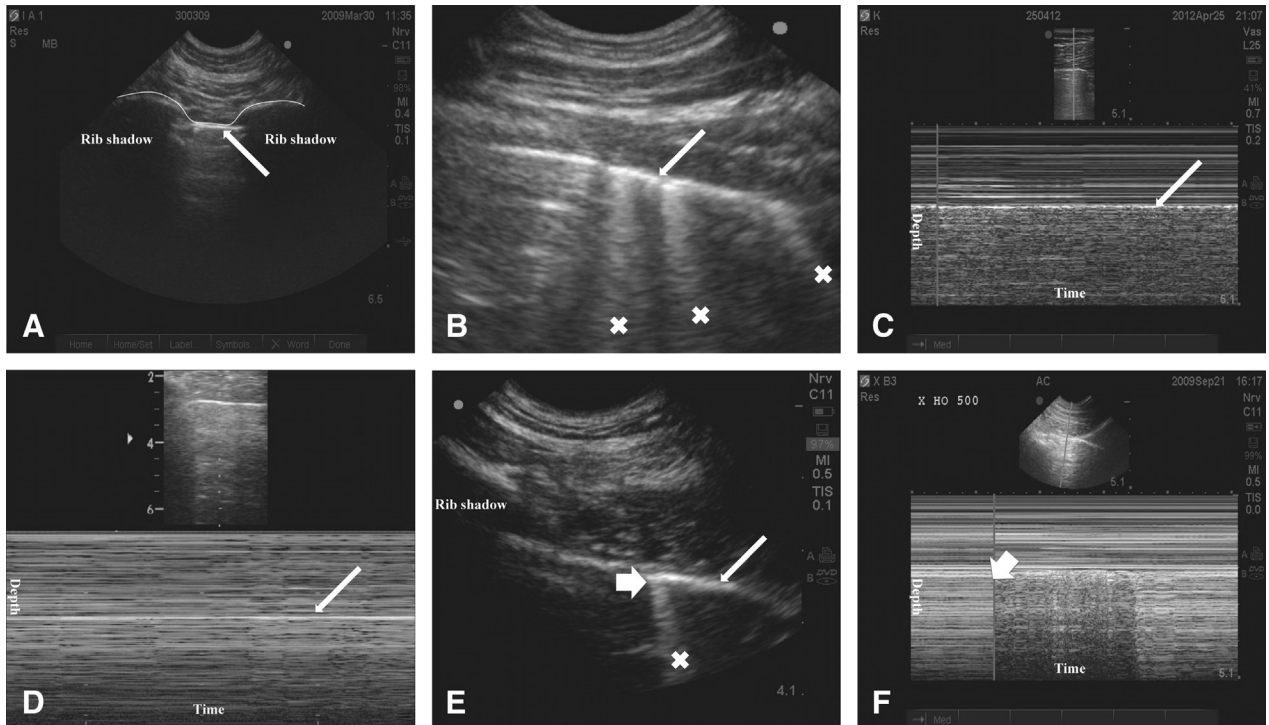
Algorithm to diagnose a pneumothorax (PTX). Throughout the figure, thin arrows point at the pleural line and X marks artifacts extending from the pleural line to the bottom of the screen, called B-lines. Thick arrows indicate the lung points. (A) The bat sign: On a longitudinal scan at the anterior chest, two ribs with the pleural line in-between are identified (this image resembles a bat, as shown by the thin white line). (B) Detection of lung sliding or B-lines: This image is obtained by rotating the probe approximately 90 degrees to align in the intercostal space and then gradually moved toward the lateral-posterior parts of the chest. The aim is to detect the presence or absence of horizontal movements of the pleural layers, called lung sliding (visible only on video clips) or B-lines. Lung sliding or B-lines rule out PTX, and both signs are absent if the pleural layers are separated by air. (C) Seashore sign: Time motion-mode from image B. When lung sliding is present, the image has a granular appearance under the pleural line (resembling sand) and horizontal lines above the pleural line (resembling the horizon). (D) Stratosphere sign: Abolished lung sliding can also be visualized in time motion-mode. Notice here the straight horizontal lines throughout the image in contrast to image (C). (E) Lung point: The boarder between the intrapleural air and the part of the lung still in contact with the interior chest wall is called the lung point (thick arrow). It appears on the screen as two distinct sonographic patterns that interchange synchronous with respiration (visible only on video clips). Identification of the lung point is 100% specific for PTX. (F) Lung point in time motion-mode: The interface between the seashore and stratosphere pattern is the lung point (thick arrow).
